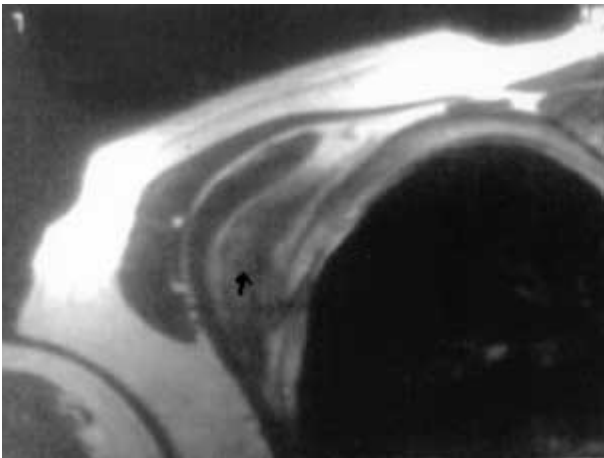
Magnetic resonance imaging findings in case 1. The tumor is located between the rib cage and left scapula.
